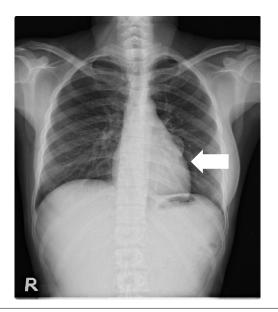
Chest x-ray shows a well-defined nodular density at the left hilar region.
